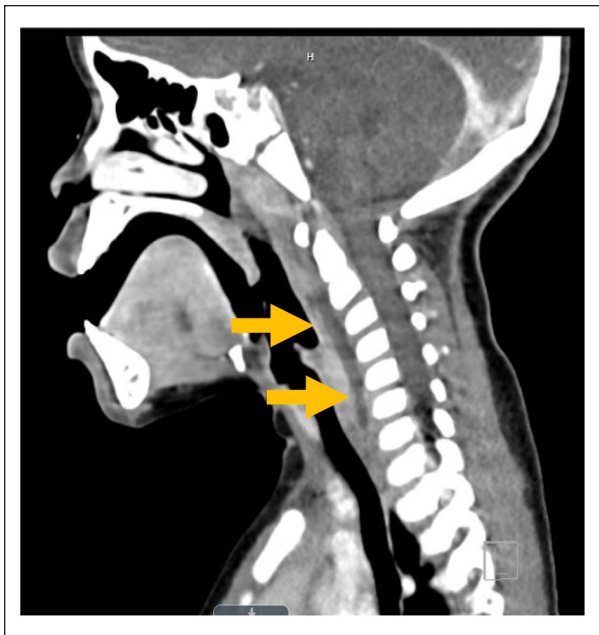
CT taken on admission showing retropharyngeal phlegmon measuring maximum 5 mm in diameter extending from the clivus to approximately the C6 vertebral body.
